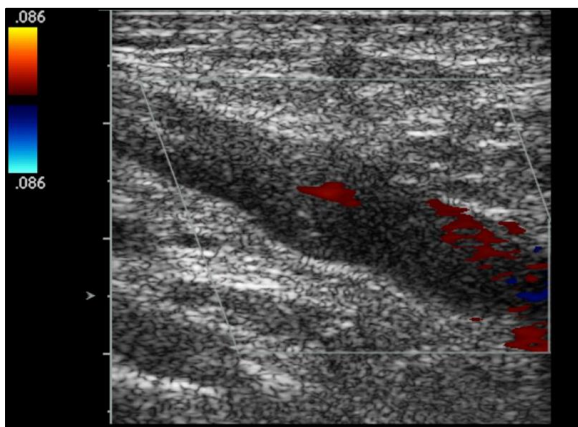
Venous doppler of right lower limb reveals hypoechoic thrombus within the right popliteal vein with no internal flow; No obvious compressibility - suggestive of acute deep vein thrombosis.
